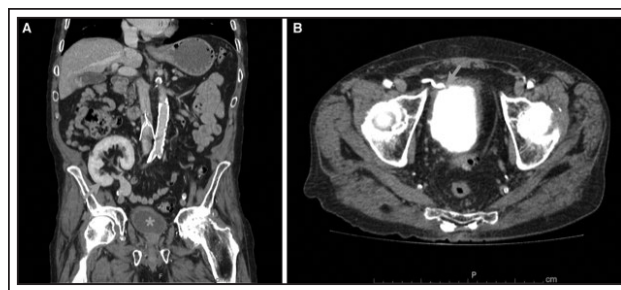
(a) Coronal view of the computed tomography of the abdomen and pelvis with contrast showing the transplanted kidney (arrow) and thickened bladder wall (star). (b) Axial view of the computed tomography of the abdomen and pelvis with contrast showing the transplanted ureter entering the dome of the bladder with bladder wall thickening at the ureterovesical junction (arrow).
